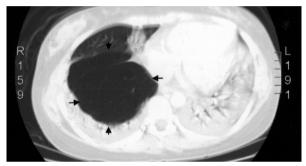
Chest CT taken on day 1 showing bilateral consolidation with a right lower lobe hypertranslucent lesion suggestive of bullae.
